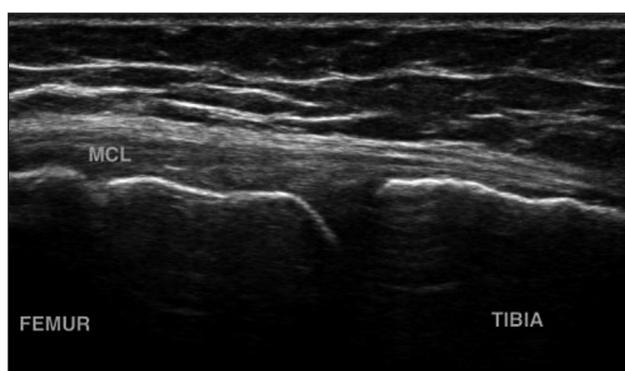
An ultrasound image with a fully torn MCL in the bone portion of the tibia, pulled and retracted towards the head (the femur)
